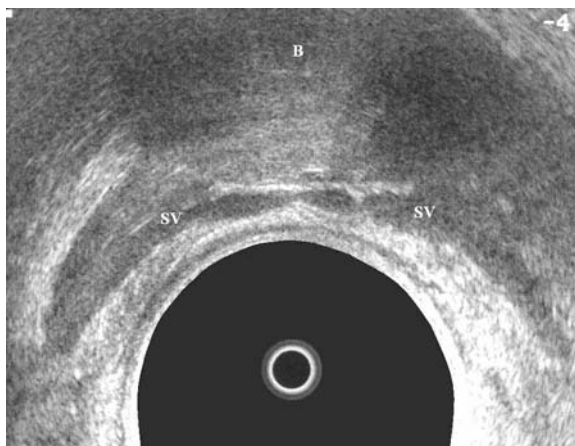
35. Sonographic view of the bladder (*B*) and seminal vesicles (*SV*)
